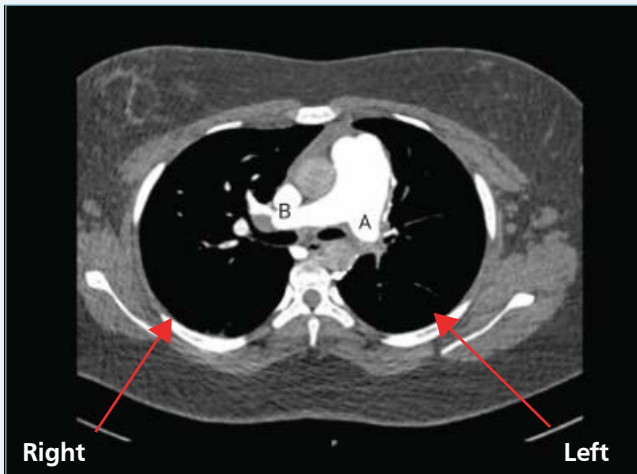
CT pulmonary angiogram (sagittal section) showing Left pulmonary artery is occluded at the mediastinum with paucity of distal branches(A). Luminal narrowing of right lower lobe pulmonary artery branch is seen(B).
